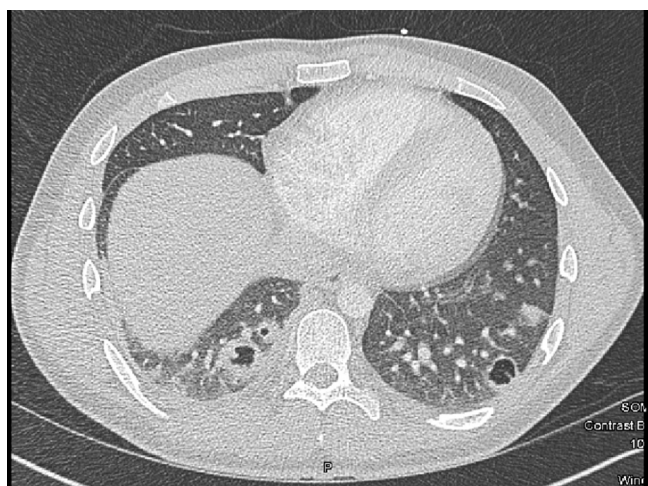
CT angiogram with contrast showing new multiple cavitary lung masses, suggestive of septic emboli, and trace right pleural effusion.
